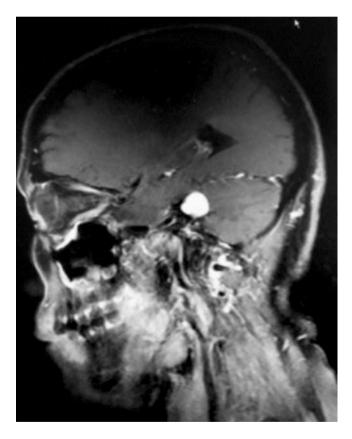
Weighted sagittal MRI T₁WI shows: acoustic neuroma
